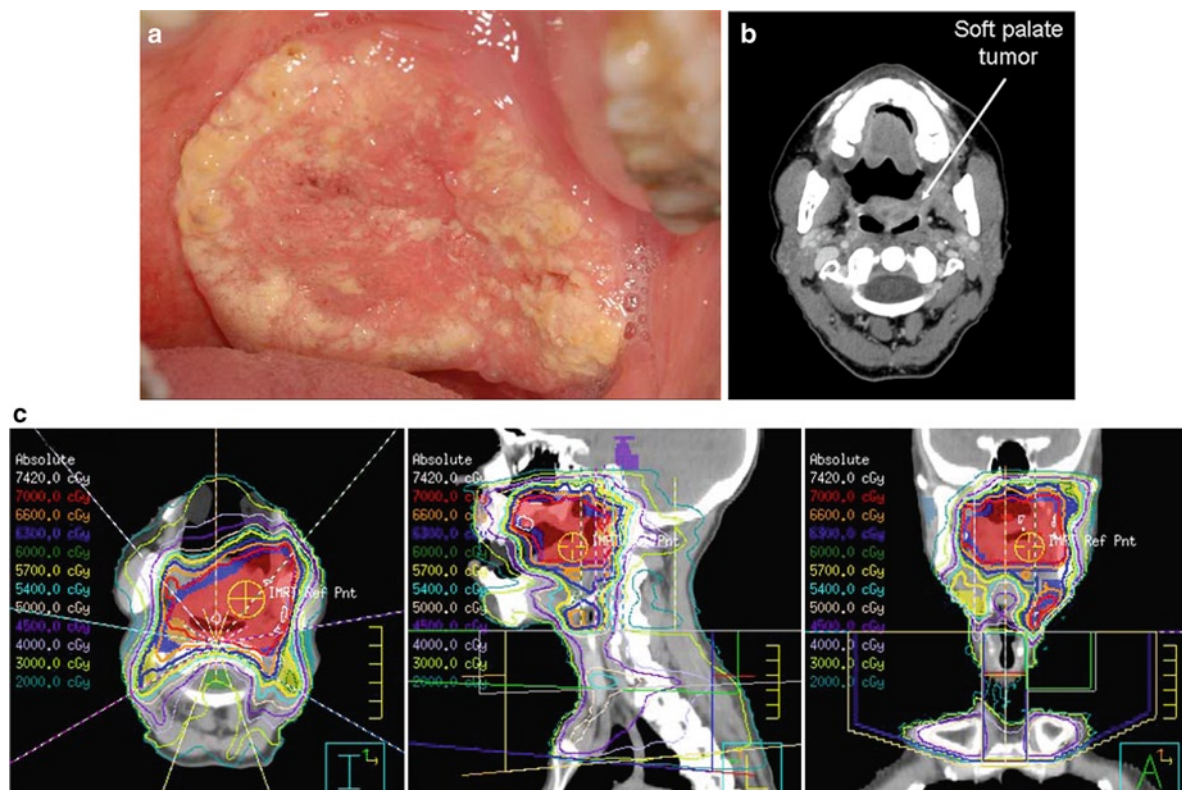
Soft palate tumor (a) Initial clinical presentation of a T4 N1 squamous cell carcinoma of the soft palate (b) Initial contrast-enhanced CT appearance of the same T4 N1 squamous cell carcinoma
